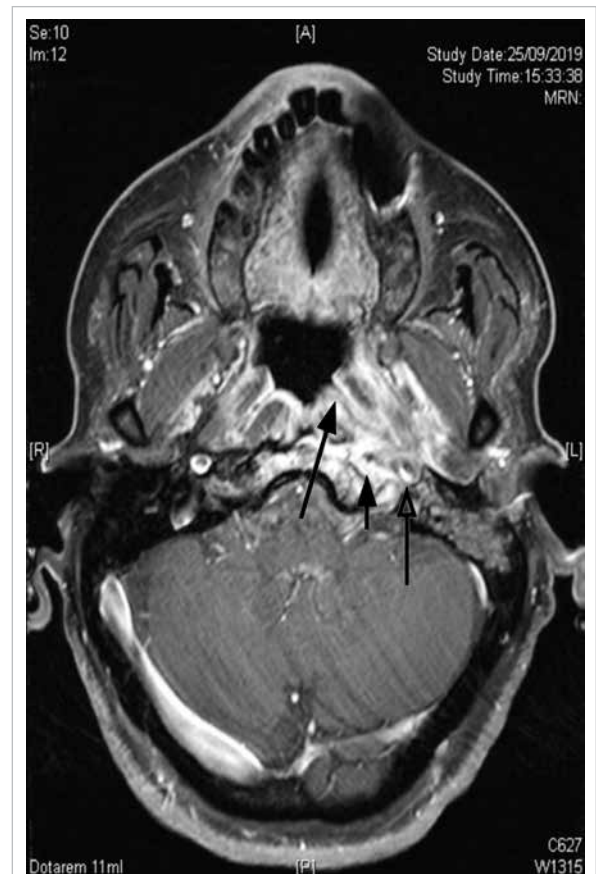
Patient 1. Gadolinium-enhanced magnetic resonance image showing enhancing signal intensities in the left nasopharynx involving multiple skull base structures, including the left fossa of Rosenmuller (long arrow), left prevertebral muscle (short arrow), and left carotid canal (open arrow)
